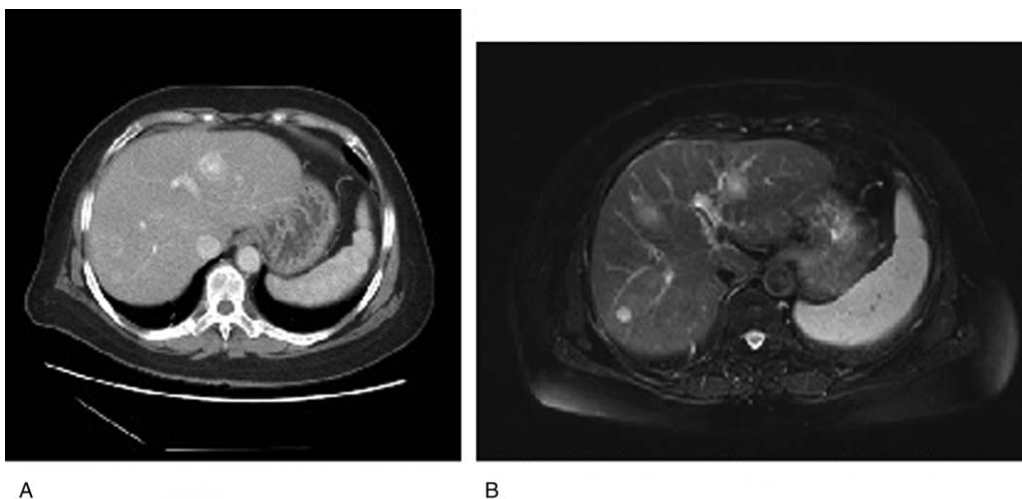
Computed tomography during arterial portography. (A) A hypervascular tumour with area of necrosis in both liver lobes, measuring 3.76 × 2.51 cm at the largest dimensions. (B) Pre-operative hepatic magnetic resonance imaging, T₁-weighted gadolinium contrast.
